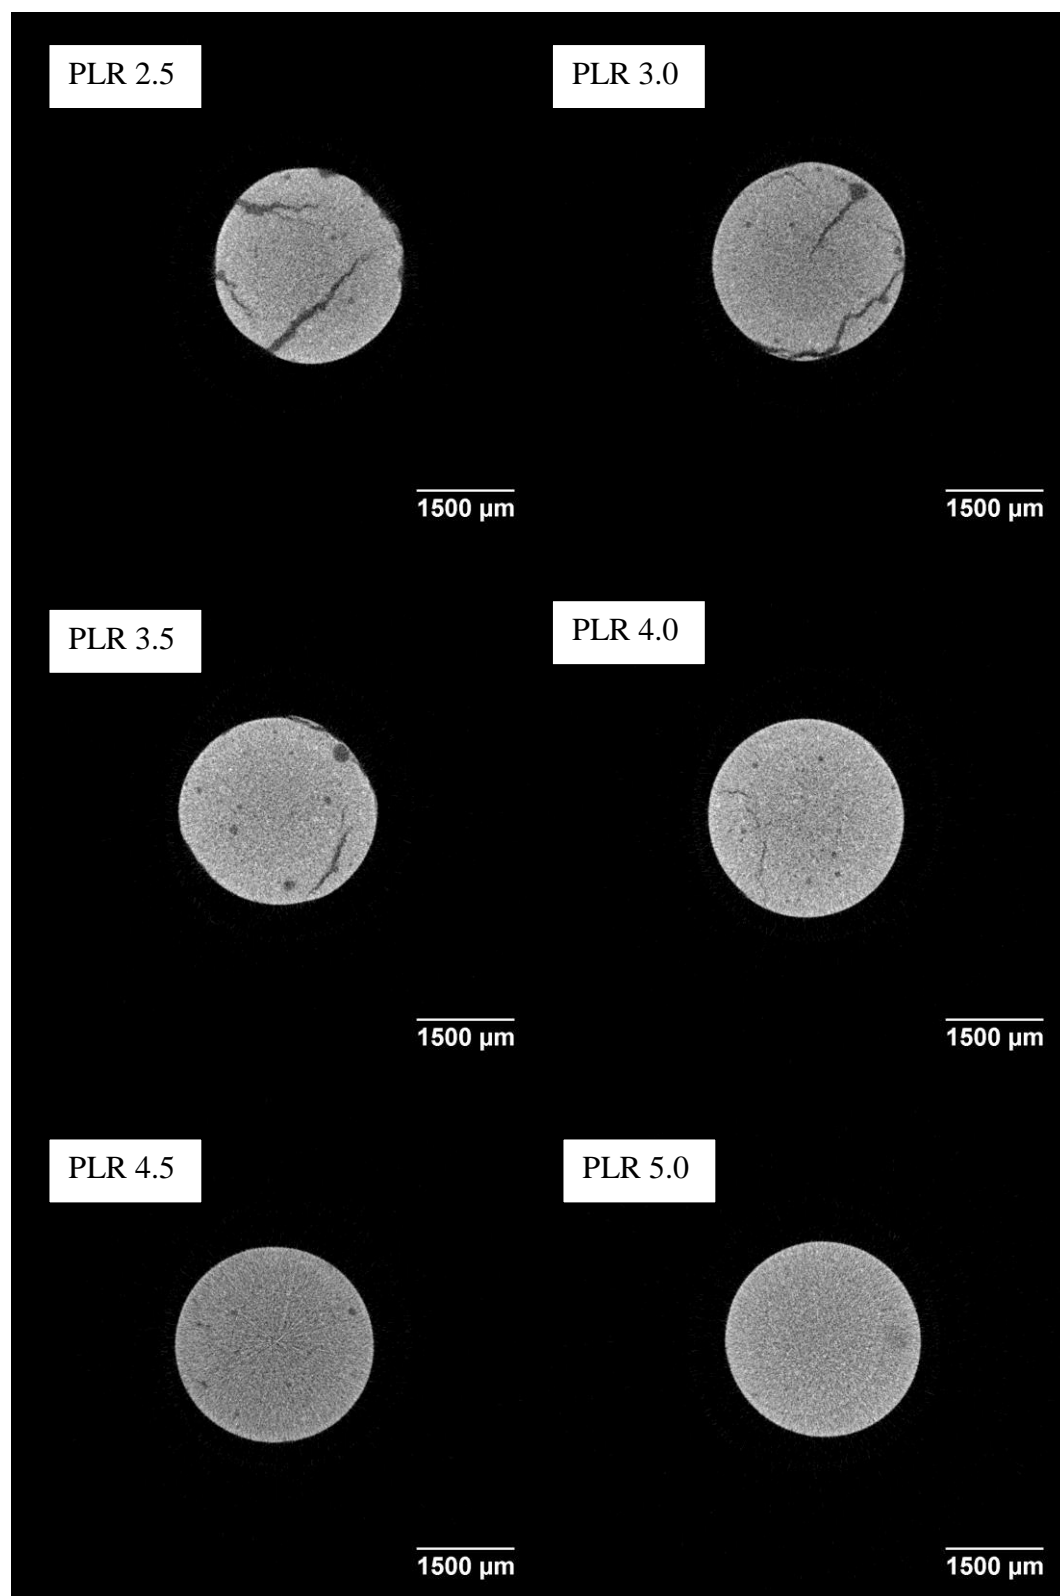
μ -CT images depicting the cross-section of a Portland cement standard disk with a 6 mm diameter ranging from a powder-to-liquid ratio of 2.5-5 g/ml.
